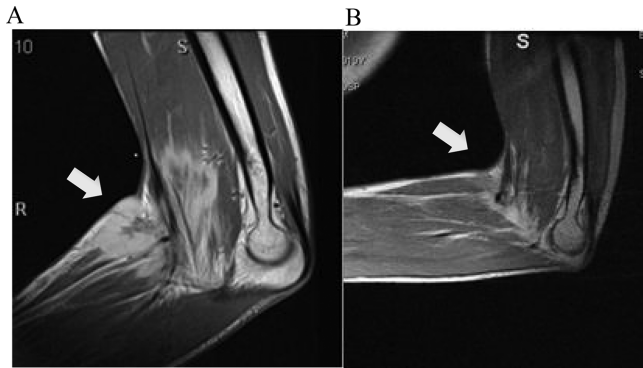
Patient 1—A, Magnetic resonance imaging at second local relapse of the inflammatory myofibroblastic tumor in the elbow; B, regression after 2 months of treatment with ceritinib
